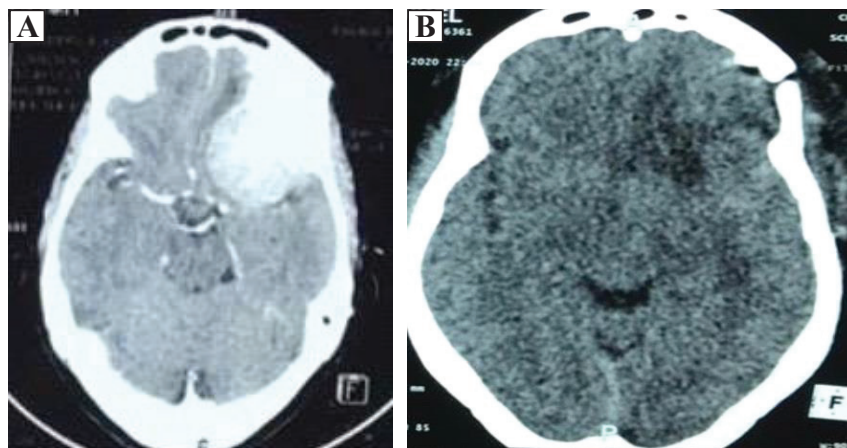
Sphenoid wing meningioma (A: preoperative CT scan; B: postoperative CT scan)
